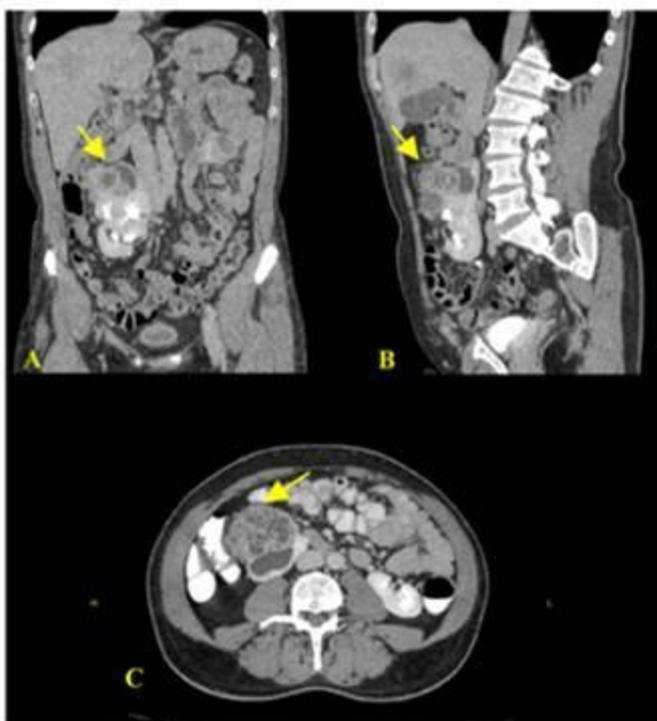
Abdominal CT (Yellow arrows demonstrate renal mass) A. Frontal plane of imaging. B. Saggital plane of imaging C. Transverse plane of imaging.
